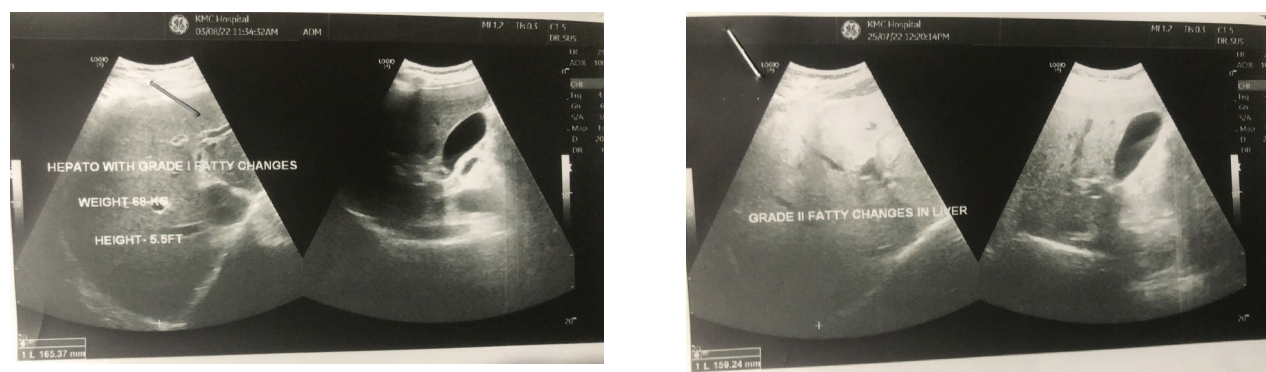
Ultrasonographic picture of fatty liver changes grade I (Left) above and Grade II (Right) below
